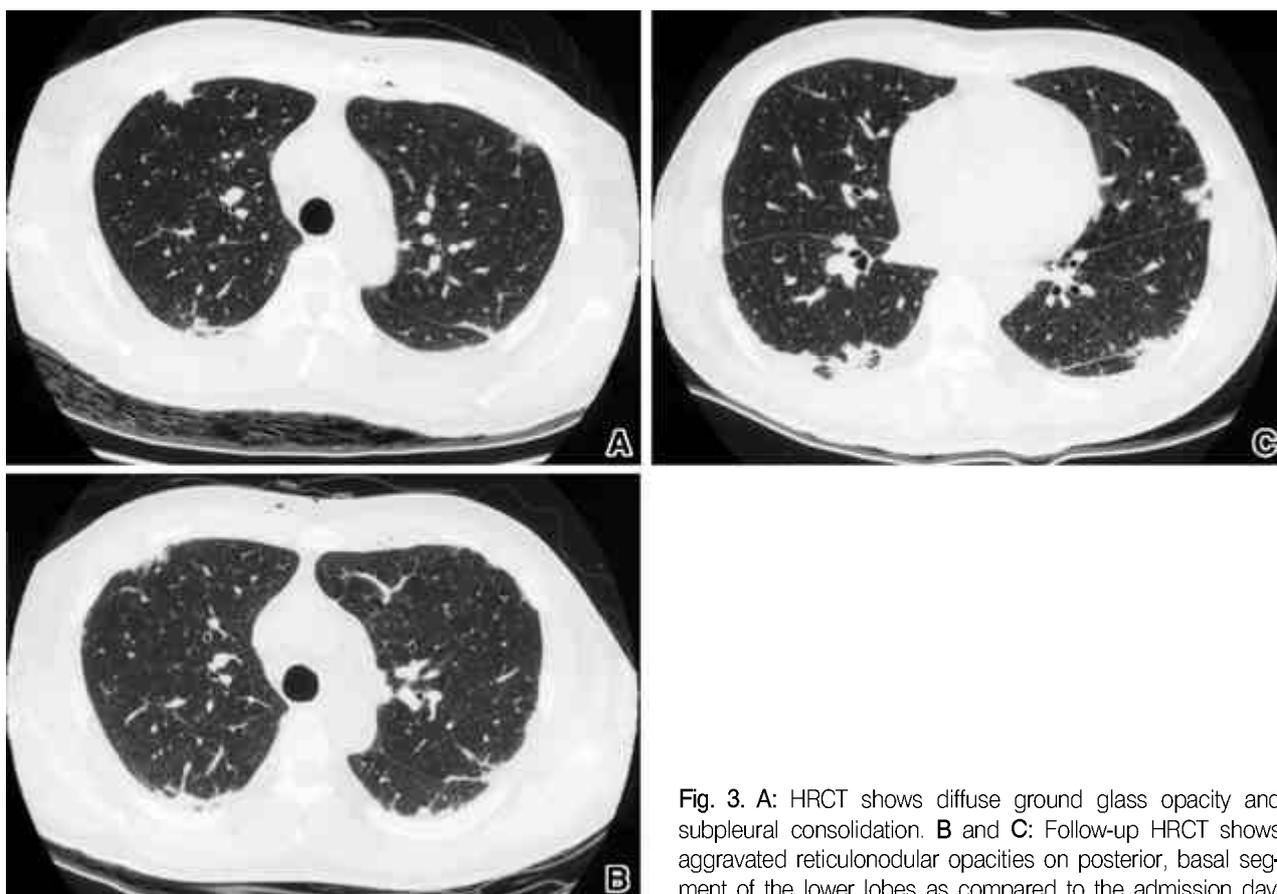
A: HRCT shows diffuse ground glass opacity and subpleural consolidation. B and C: Follow-up HRCT shows aggravated reticulonodular opacities on posterior, basal segment of the lower lobes as compared to the admission day.
